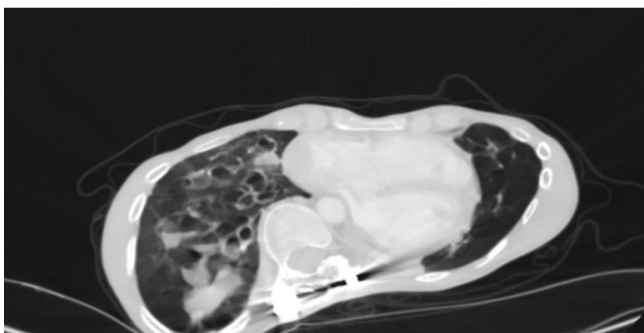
A homogeneous increase of density with an appearance of "finger in glove" (bronchocele) on the right, diffuse bronchiectasis areas in the right lung middle lobe and right lung lower lobe superior segment. The appearance of consolidation and ground-glass in the left lung on Thoracic CT
